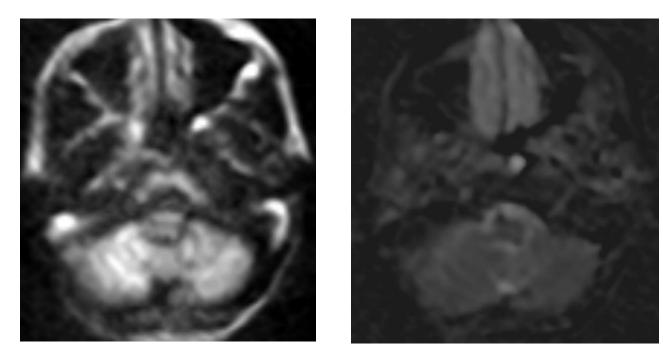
MRI axial image: non-echoplanar diffusion weighted sequence (right) showing right attic mass of restricted diffusion appearing of bright signal intensity and returning hypointense signal intensity on ADC (left image) denoting cholesteatoma.
